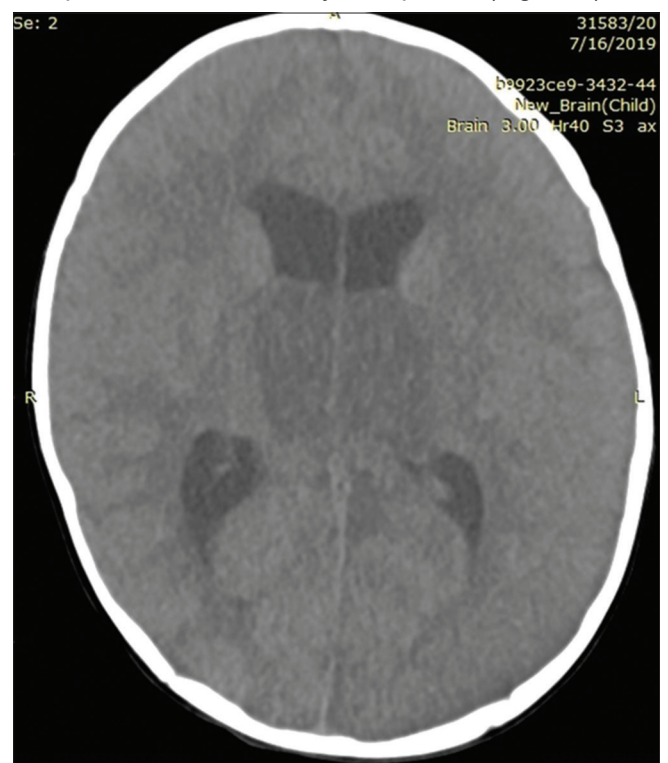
Computed tomography scan of the brain-enlargement of the lateral ventricles, with intraventricular masses and pronounced internal hydrocephalus
